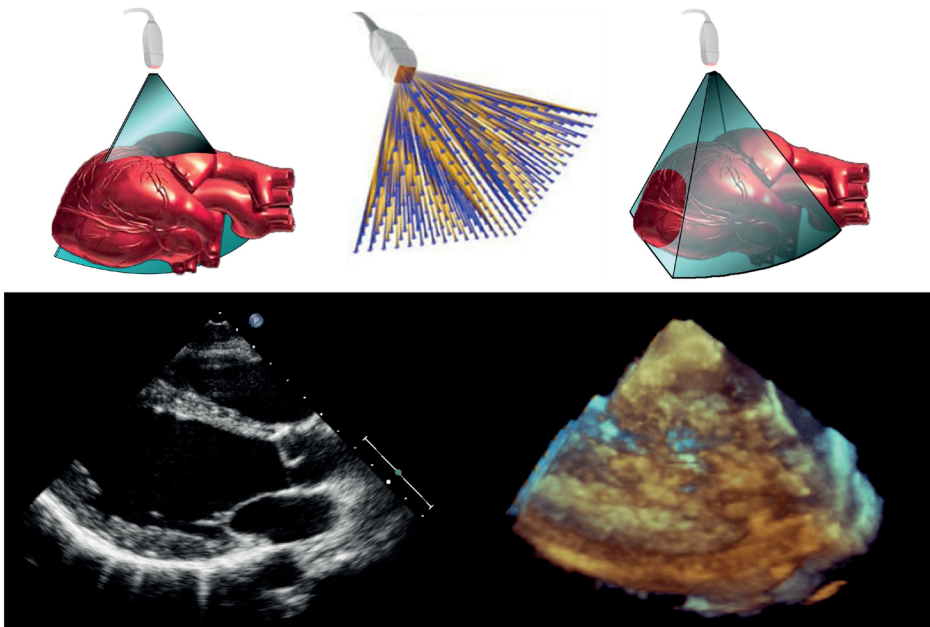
The matrix-array transducer: 2D to 3D echocardiography. (Left 2D B-mode, center matrix-array transducer, right 3D echocardiography)
